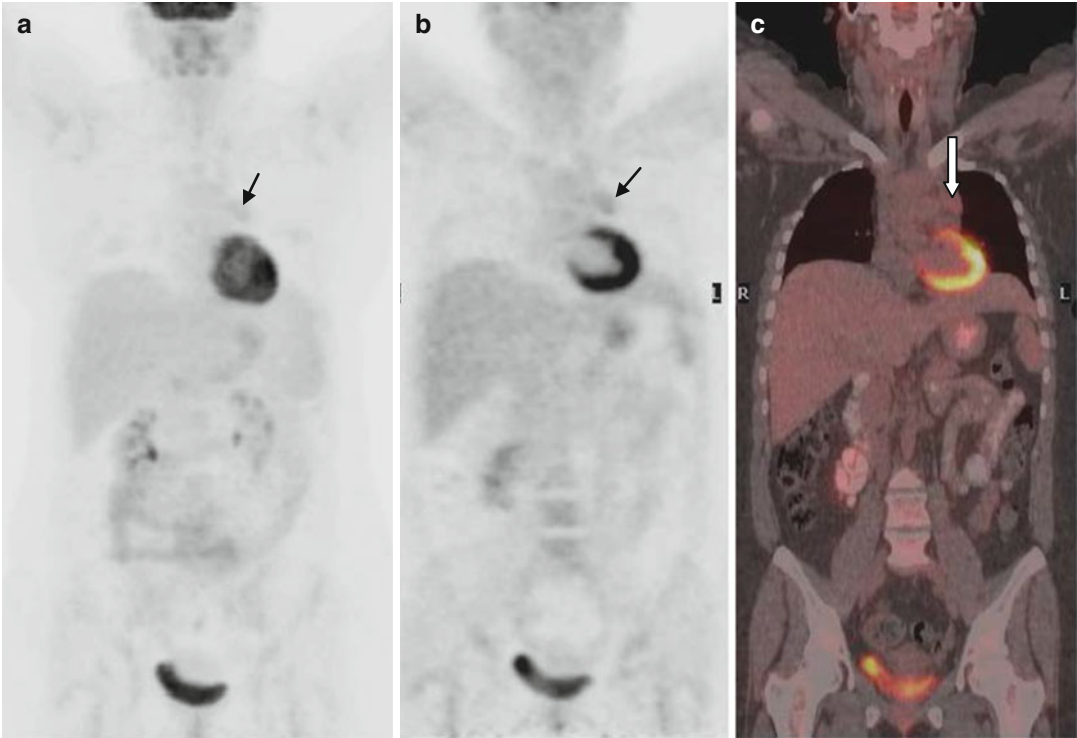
(a–c) Interim PET/CT revealed low-grade 18-FDG uptake (SUVmax 2.6) corresponding to a D-5PS score 3
